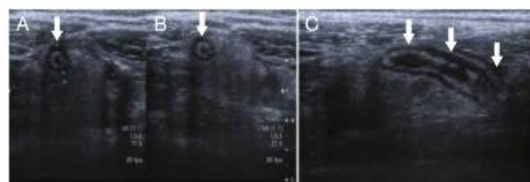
• Ultrasound imaging in appendicitis. Arrows show a distended appendix with a thickened wall. A and B show transverse views of the appendix. C shows a longitudinal view of the appendix.
